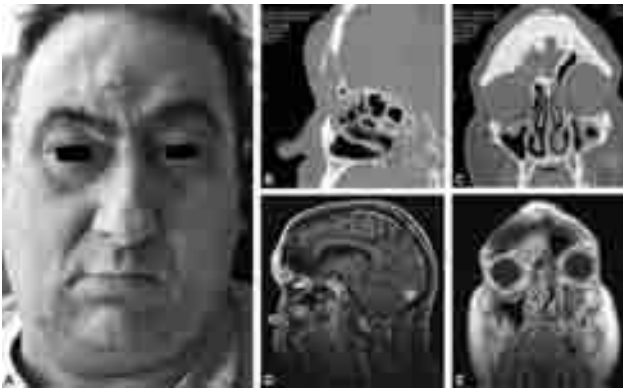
Presentation of the patient. (A) Initial presentation. (B, C) CT scan (sagittal and coronal plane): frontal right sub-cutaneous collection anterior to a synthetic metal plate; osteomyelitis and dehiscence of the frontal anterior bone table at its junction with the frontal bone and the floor of the frontal sinus; suspected old fracture of the posterior table; lesions from bilateral, maxillary and frontal left ethmoidal sinusitis. (D, E) MRI (sagittal and coronal plane): hypersignal T1 frontal right collection with inflamed infiltration of the sub-cutaneous fat in the absence of endocranial lesions.
